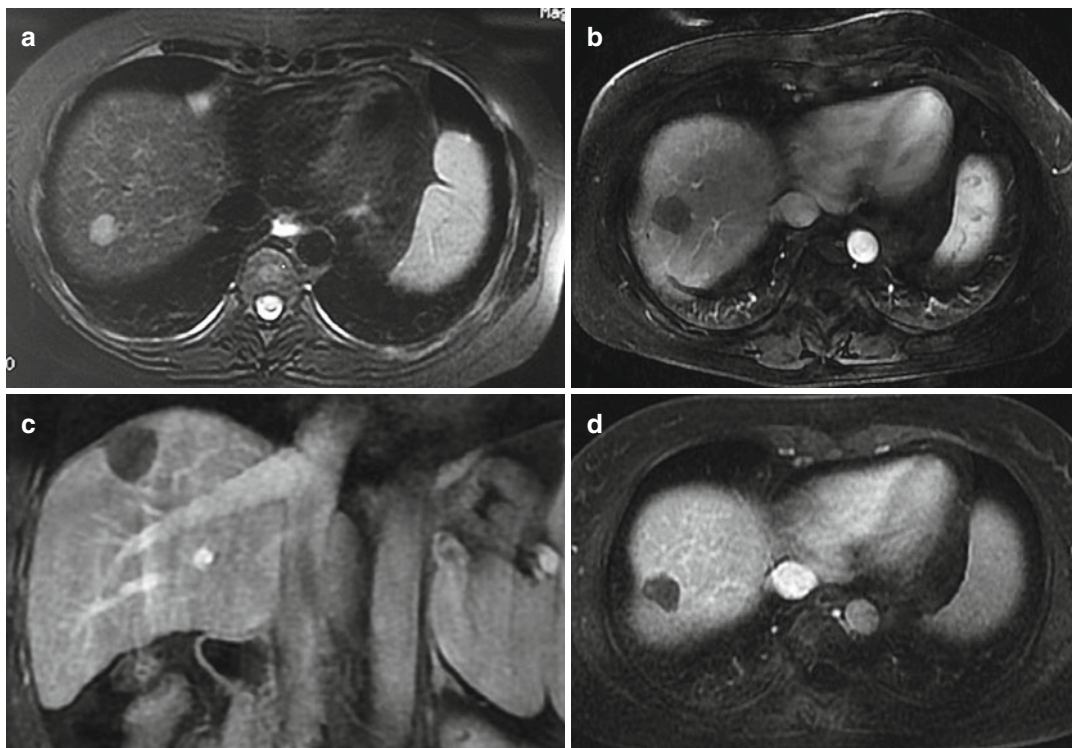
Contrast-enhanced MRI in a 42-year-old man who underwent MWA of HCC. (a) Hepatic T2 preablation image shows an HCC (*arrow*) with the size of 1.6×1.4 cm; (b) MRI scan obtained 3 months after MWA shows a signal area with no enhancement, suggestive of complete necrosis
